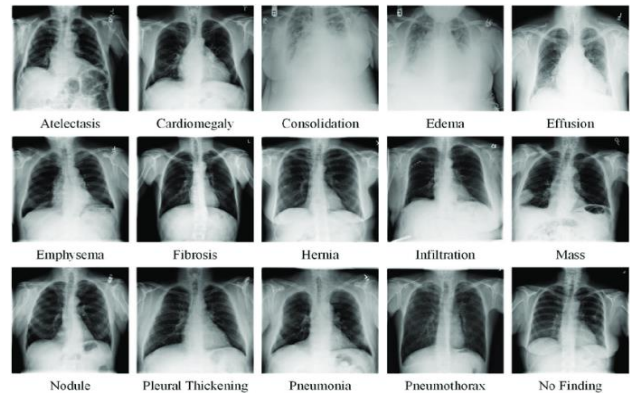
Sample images of Chest X-ray14 dataset
